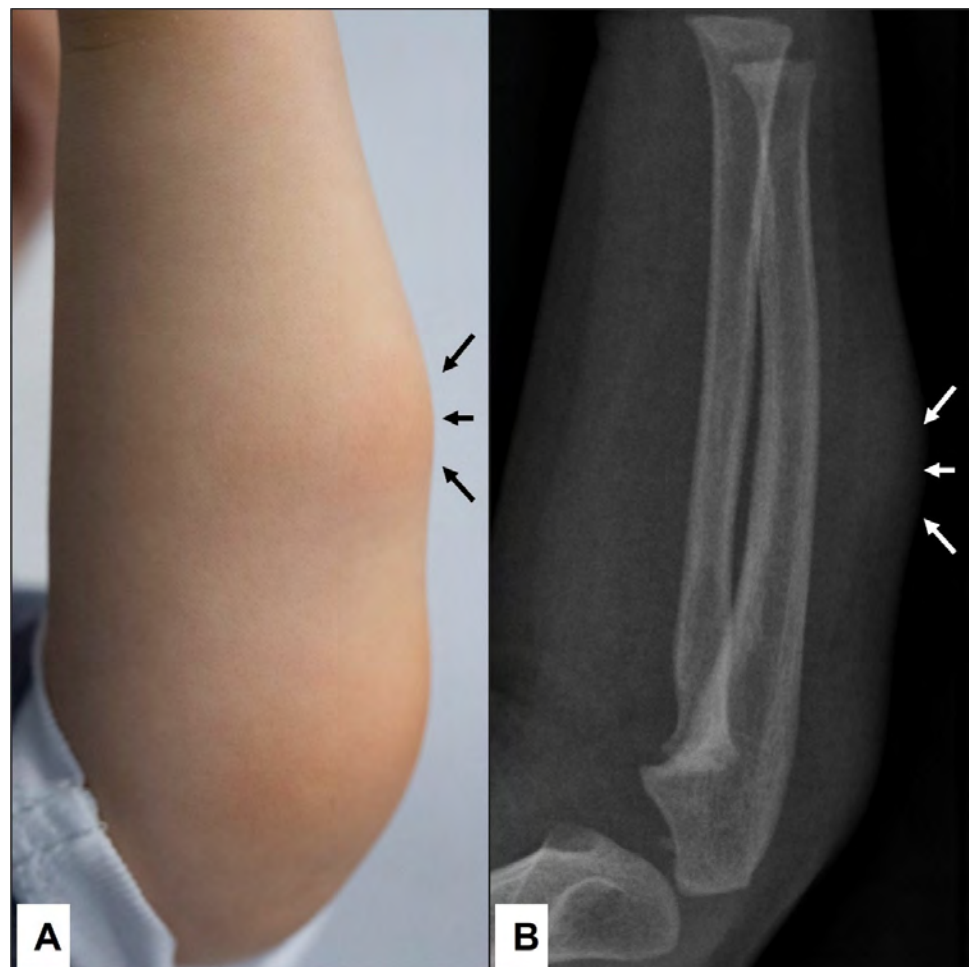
A 2-year-old boy was presented by his parents due to the swelling on the left forearm, which persisted for the last 2 months (A)—(black arrows). Because the subcutaneous lump was firm and immobile, an X-ray was conducted to exclude bone abnormalities (B). Note the homogenous soft tissue expansion in the subcutaneous area (white arrows) but no osseous involvement.
